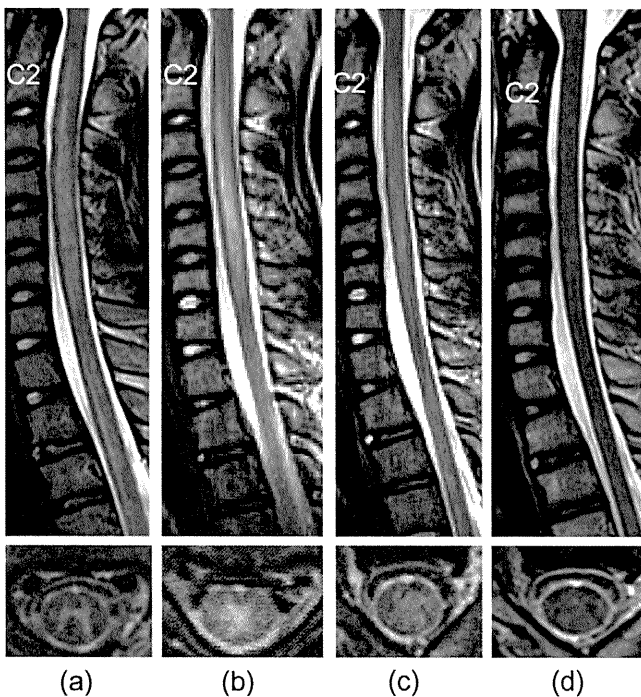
T2-weighted spinal cord lesions. (a) 7 days, (b) 12 days, (c) 15 days, (d) 41 days, after neurological symptoms developed.
